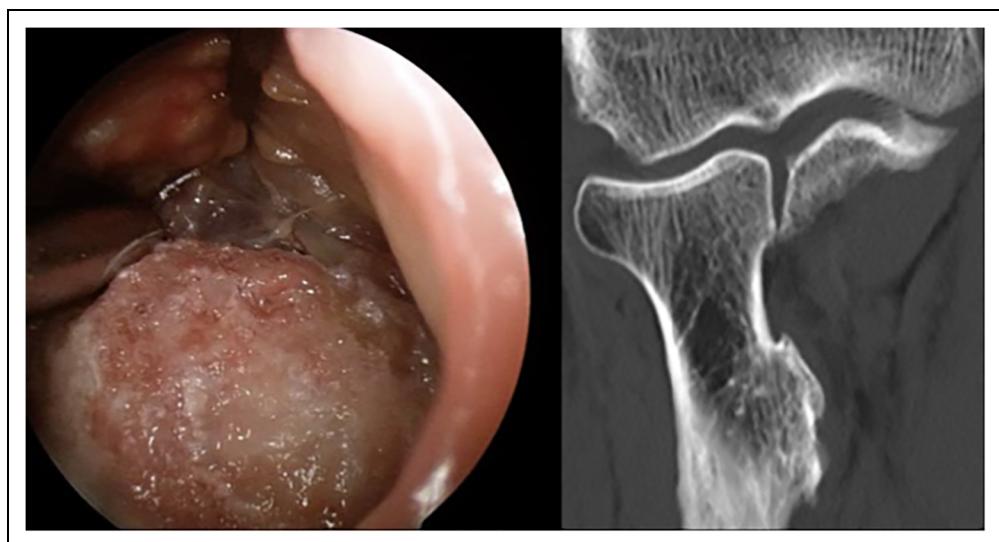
CT scan and intra-operative view of a patient with degenerate tendinopathy and partial tears with clicking and reduced pronation. The tendon was released and repaired and the tuberosity debulked to restore full pronation. Copyright Mr Joideep Phadnis.
